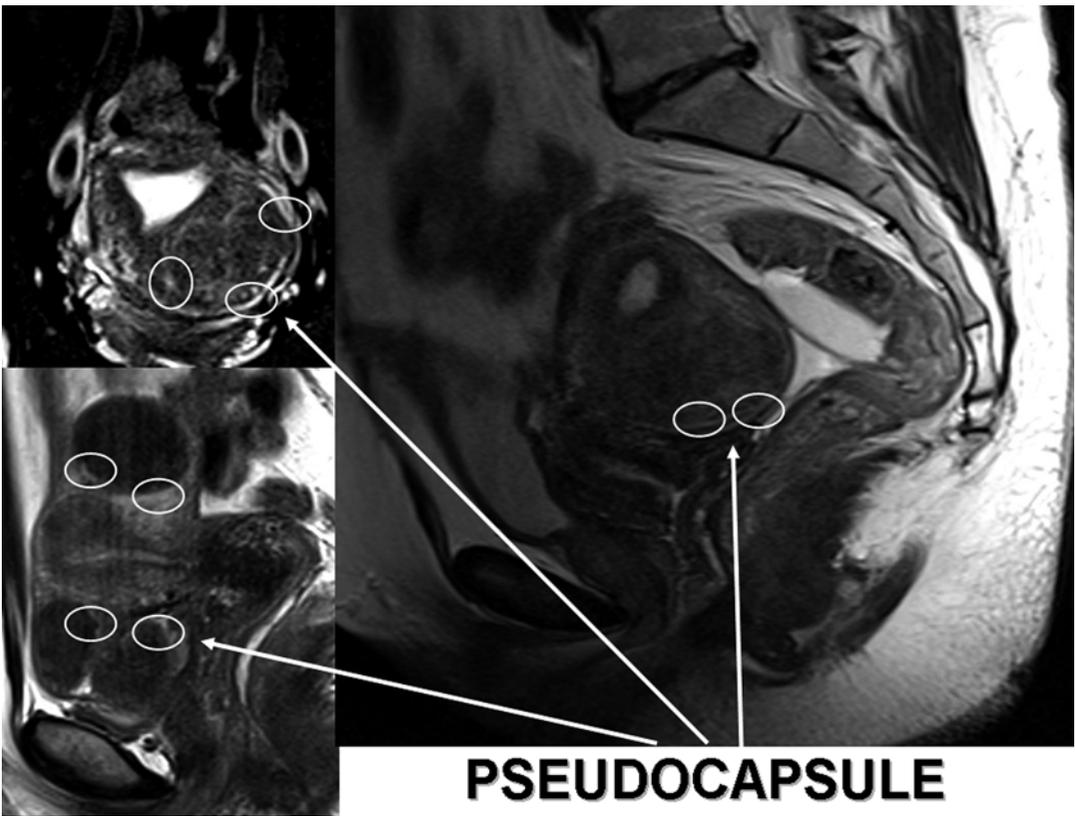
MRI reconstructions of myomatous uteruses. The white arrows indicate white rings enhancing myoma pseudocapsules
